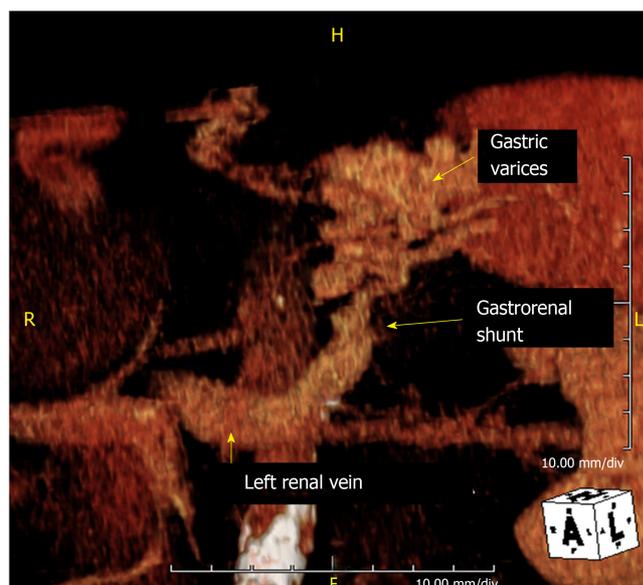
Gastrorenal shunt at computed tomography scan.
